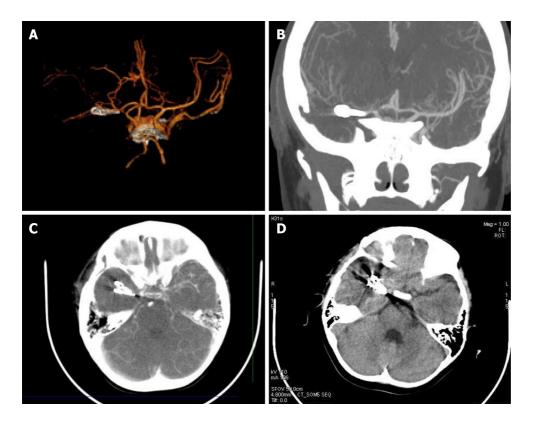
Postoperative computed tomography angiography examination and follow-up. A-C: Postoperative computed tomography angiography examination indicated that the aneurysm had been resected, and the blood flow of the constructed medical council on alcohol was unobstructed; D: The 3-year followup showed no recurrence.
